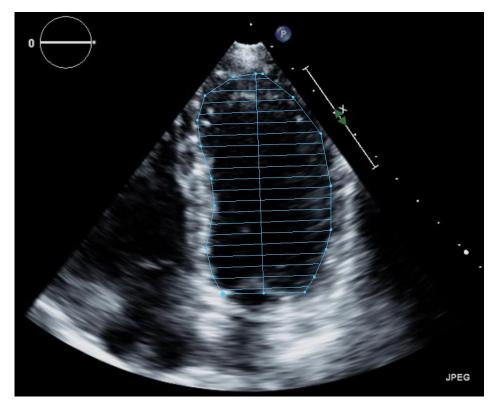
Two-dimensional echocardiography apical four chamber view of the left ventricle used for Simpson's biplane measurement for volume calculation.
